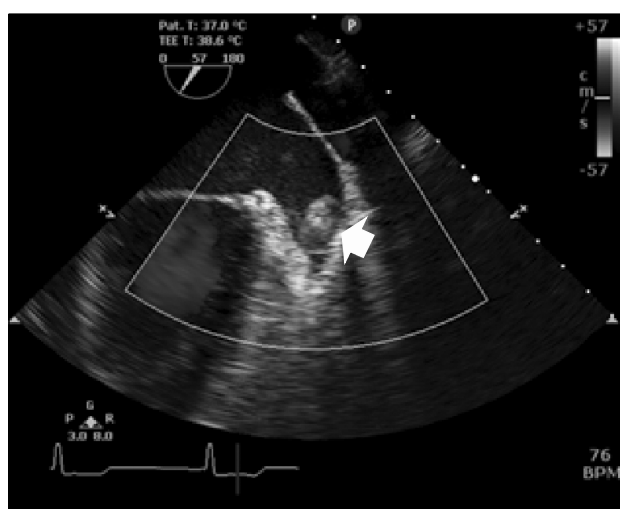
Transesophageal echocardiography image obtained before CPB showing small immobile thrombus (white arrow) of 1.3×1.8 cm in the LAA. CPB: cardiopulmonary bypass, LAA: left atrial appendage.
